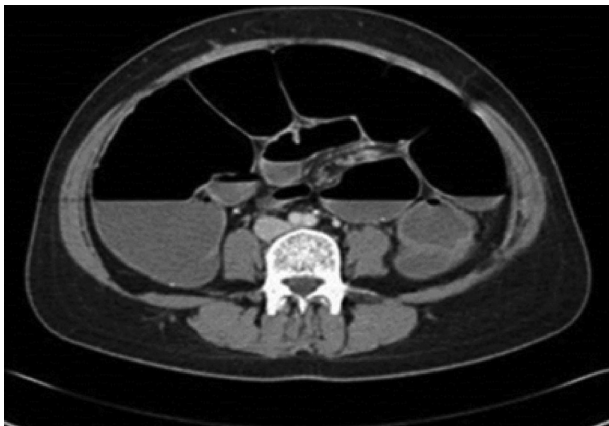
CT abdomen showing distended sigmoid colon.
